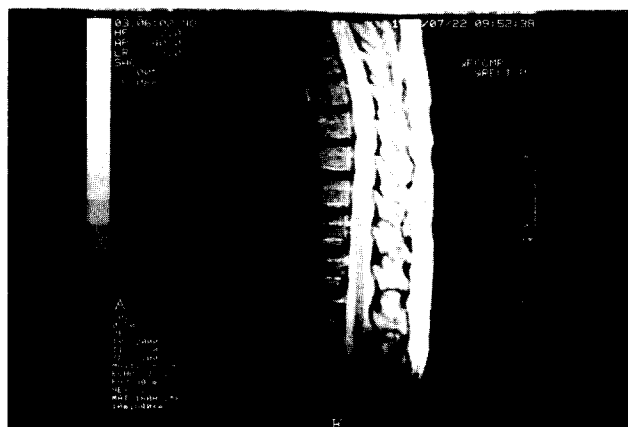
Patient's MRI scan showing a heightening of signal in the T2 sequence.
